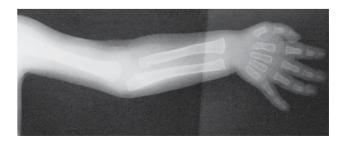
TSMG: Roentgenogram of the arm. The bones are all thickened and poorly modeled.
